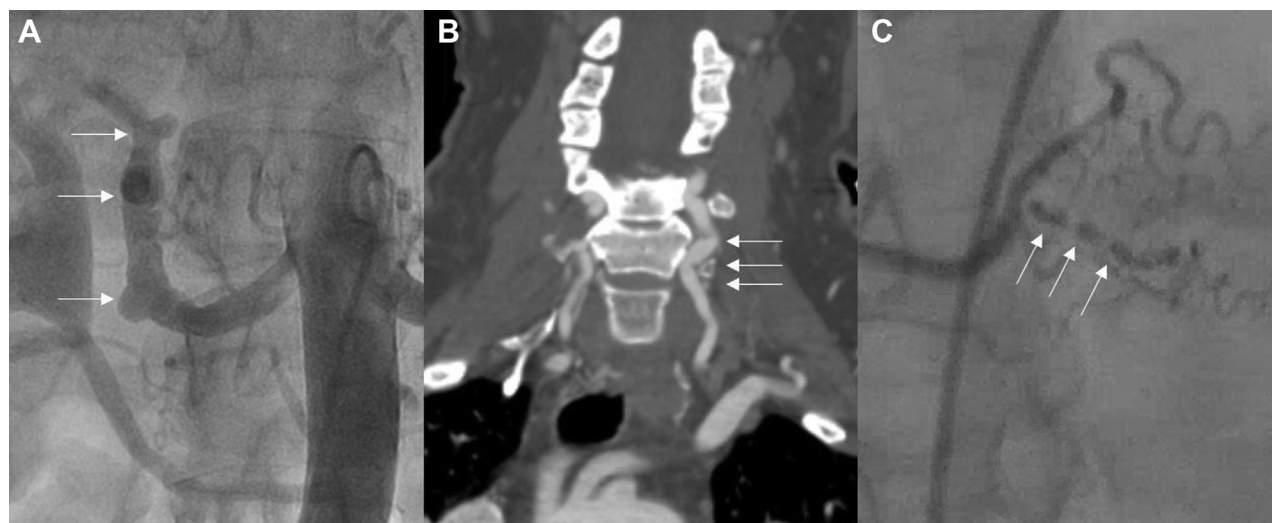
Fibromuscular dysplasia. (A) A renal angiogram was performed, which demonstrated a “beading” appearance of the right renal artery consistent with renal artery fibromuscular dysplasia (FMD). (B) A head computed tomography angiogram was performed, which showed evidence of FMD of the bilateral vertebral arteries. (C) On repeat coronary angiogram, the posterior descending artery displayed a “string of beads” appearance suggestive of coronary artery FMD.
